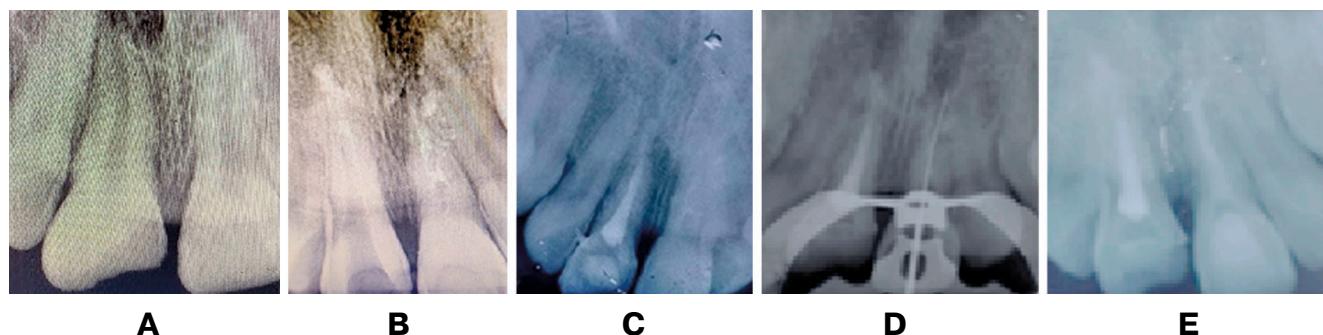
Follow-up with periapical X-ray showing proof of root resorption and complication management involving root canal treatment with biodentine plug then final obturation on both incisor 11 and 21: *A* – eight-week follow-up radiograph showing early signs of external root resorption; *B* – apexification procedure for tooth 11 showing placement of biodentine apical plug (approximately 4 mm thickness) to establish an artificial barrier at the apex; *C* – final obturation of tooth 11 with gutta-percha and sealer; *D* – working length determination confirmed with periapical radiograph on tooth 21; *E* – apexification procedure for tooth 21 with biodentine apical plug placement and final obturation of tooth 21 with gutta-percha and sealer
